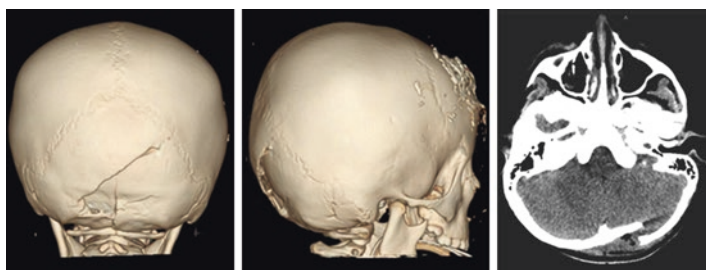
Non-contrast CT head of a 5-year-old boy who was accidentally run over by a car. There is a depressed fracture in the posterior fossa with no significant hematoma. The rest of his CT head showed no other lesions or swelling. The integrity of the underlying sinus needs to be investigated promptly
